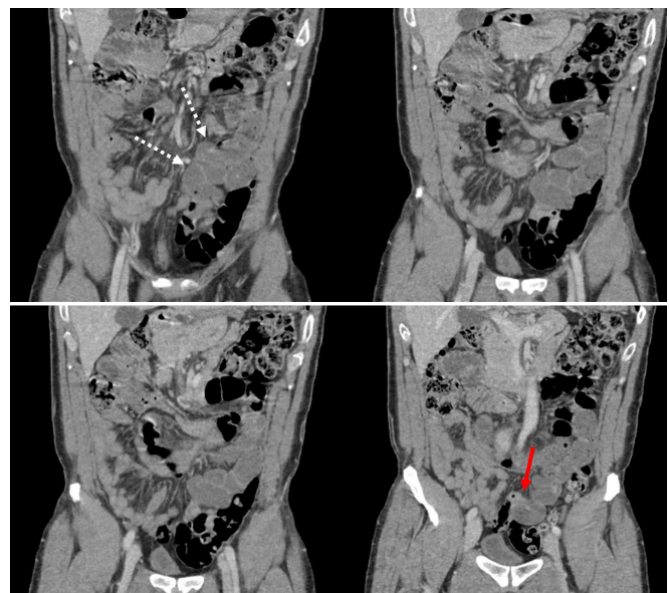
Coronal images from computed tomography scan of the abdomen and pelvis with IV contrast showing dilated loops of small bowel (dashed white arrows) and suspected transition point (solid red arrow).
